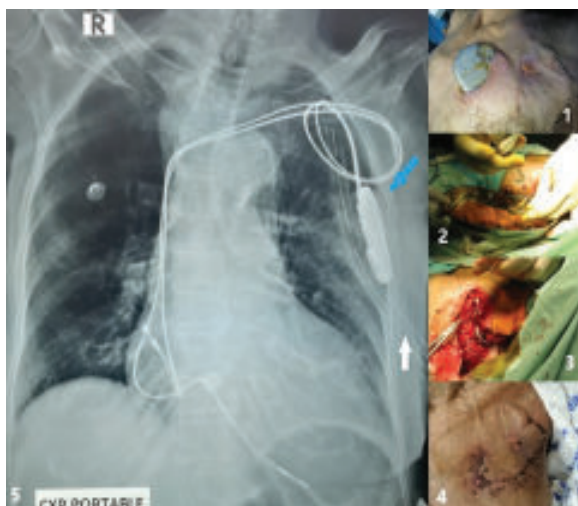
Figure panel showing 1- Skin erosion and exteriorization of the CIED generator and leads. 2- Cleansing of the pacing generator, leads and surrounding area. 3- Generator and leads pushed inside the pleural space and suture used to fix the generator to the left 3rd rib. 4- Two weeks follow up scar after all stitch removal. 5- Immediate postoperative portable X-ray Chest showing pacing generator inside the chest wall (blue arrow) and a chest drain (white arrow) in situ.
